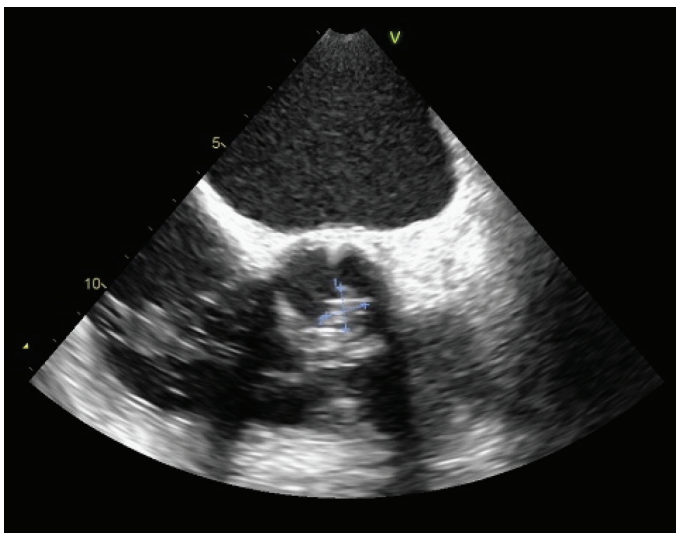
Transesophageal echocardiography showing suspected vegetation on an mechanical aortic valve.
